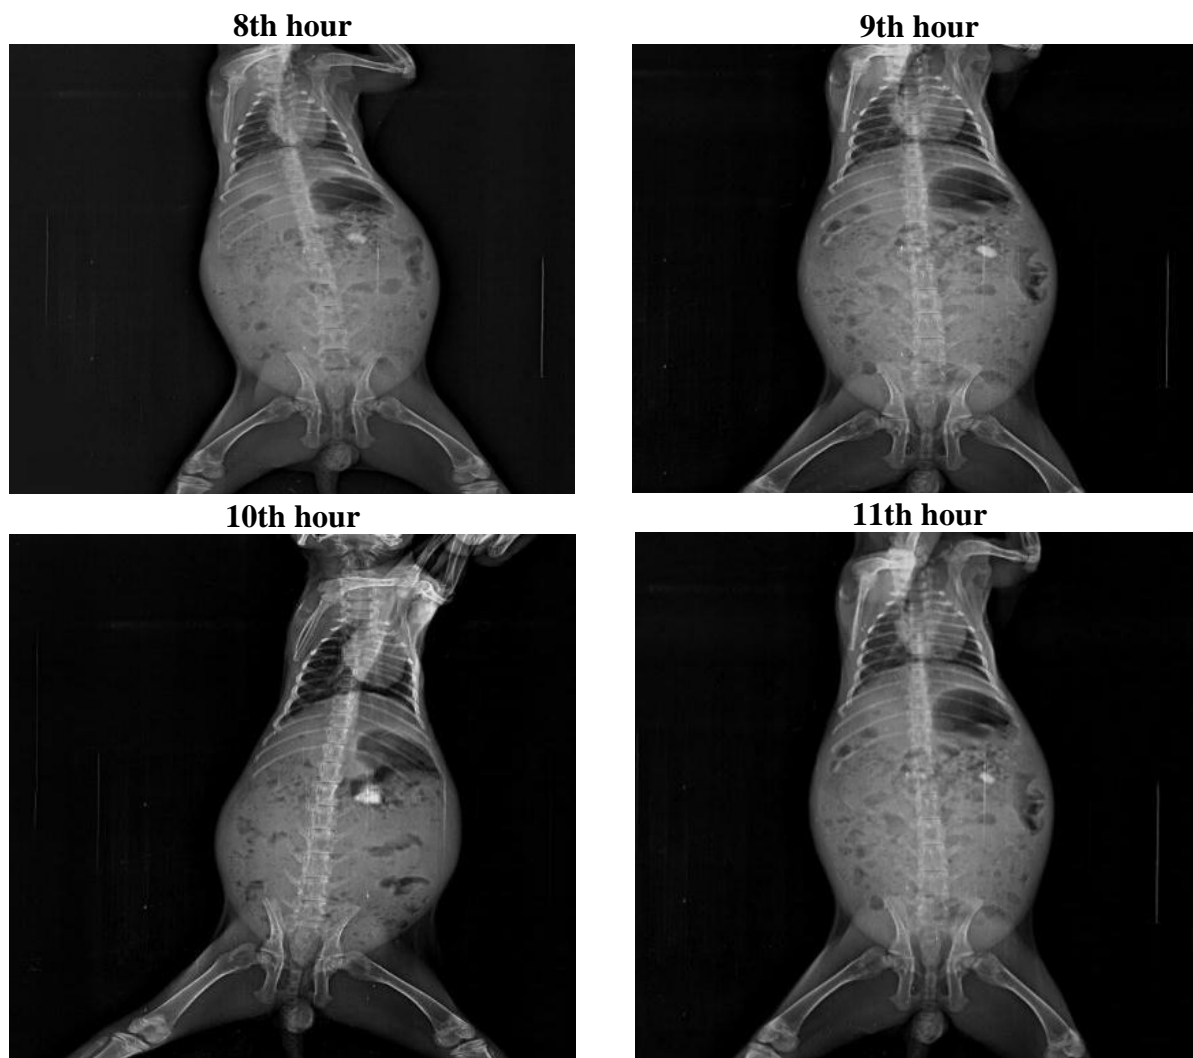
In-Vivo X-Ray Studies of Floating Tablet Of Nizatidine (F8).
